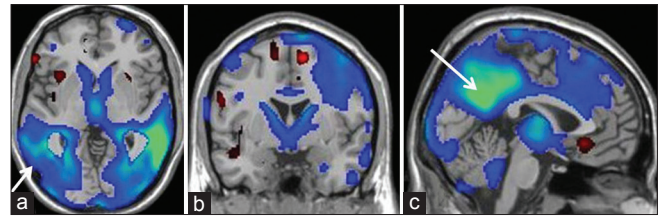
(a) SPM *t* maps of the same case superimposed on a transaxial MRI T1 template showing hypometabolism in both parietal cortices now R > L (R arrow). (b) SPM *t* maps superimposed on coronal MRI T1 template showing hypometabolism in both parietal and left temporal cortices. (c) SPM *t* maps superimposed on sagittal MRI T1 template showing hypometabolism in posterior cingulate and precuneus (arrow). In addition to hypometabolism in the parietal cortices, the extent of hypometabolism in the left parietal cortices has increased
